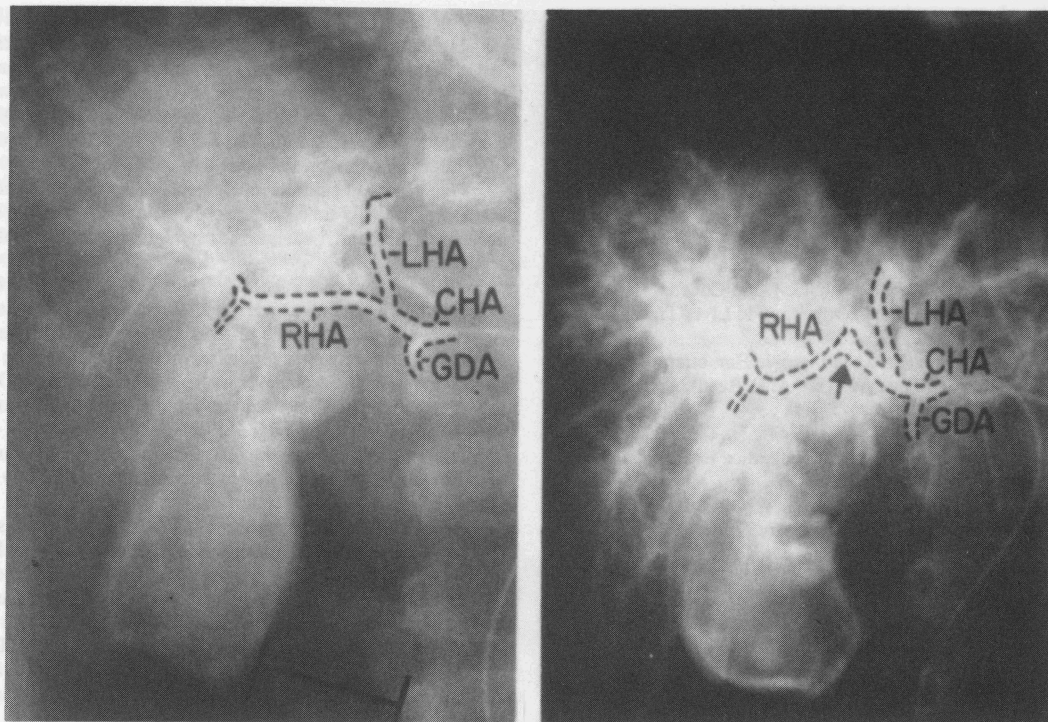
Angiographic studies performed in a 5-year-old child immediately after her death from head injuries. Dye was injected into the common hepatic artery (CHA) proximal to the gastroduodenal artery (GDA). Left — Initial injection. Note the smooth course of the right hepatic artery (RHA). Right — The restraining ligaments of the liver have been incised, a cholecystoduodenostomy performed, and the head of the x-ray table elevated to 60°. The right lobe of the liver has rotated down and medially. The course of the left hepatic artery is undisturbed. However, the right hepatic artery (RHA) is now severely kinked where it passes beneath the common duct (see discussion).
